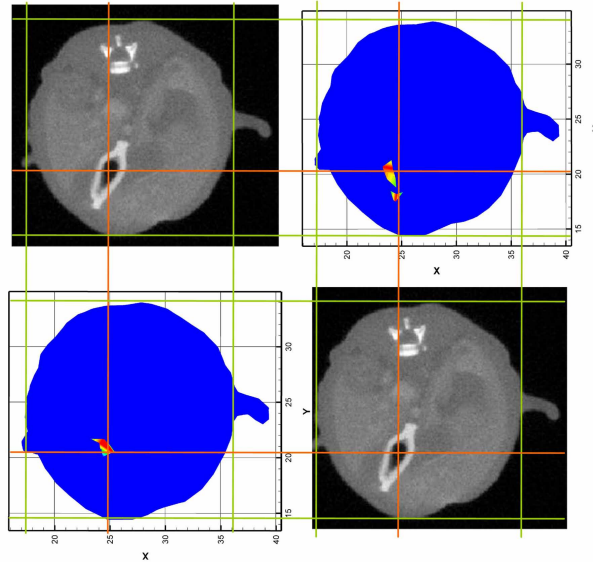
Comparisons of reconstruction results between the SP_3 and DA models. The left-bottom and right-top figures are the results of SP_3 and DA models in lateral cross sectional views, respectively, compared with the source location in the corresponding CT slices. It is noted that all the reconstructed values above zero in the slice are displayed for the results.
